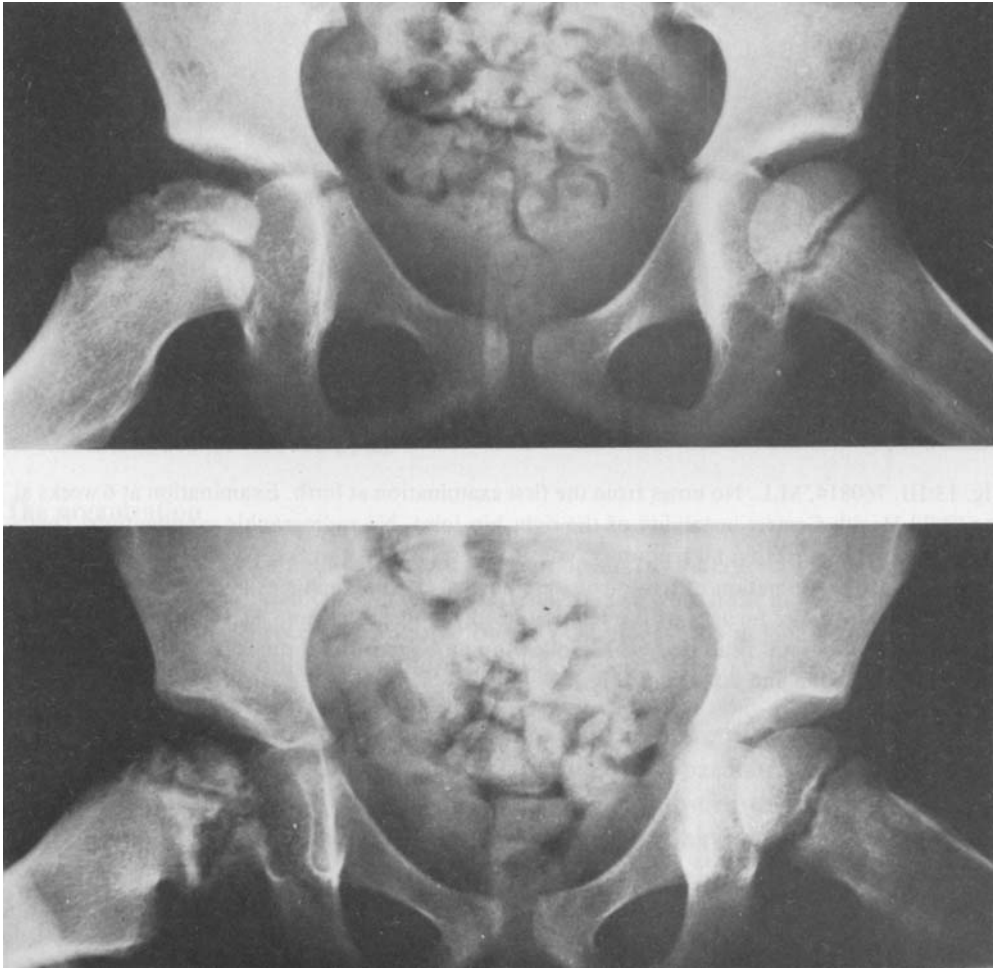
II. 760930, N.S. Older sister: preluxation at birth. Hip joint instability suspected at birth, but at a second examination nothing abnormal observed, as at the first examination at the Child Health Centre. At 3 1/2 months limited abduction of the right hip joint. Radiographic examination: dislocation of the right hip joint. Treatment: reduction relatively easy under general anaesthesia (no traction therapy, no tenotomy). Plaster for only 3 months because of dermatitis. Later on avascular necrosis of the femoral head and neck. Follow-up at 4 1/2 years: sequelae of necrosis (Figs ).
